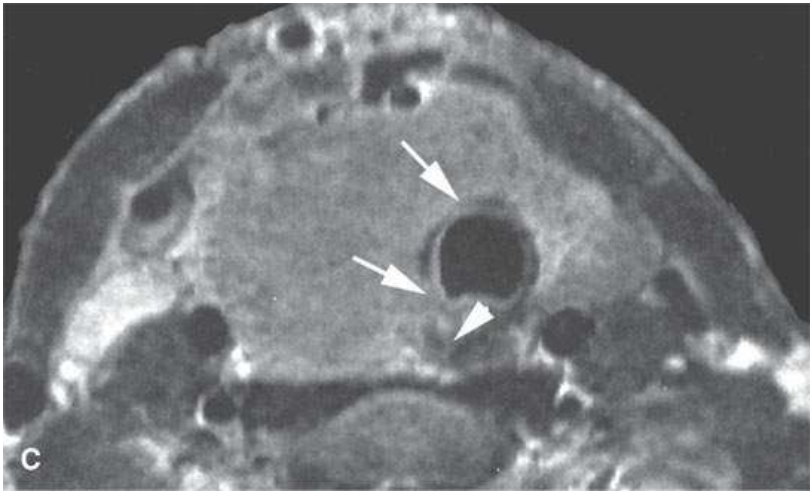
Three patients with anaplastic thyroid carcinoma. A: Contrast-enhanced computed tomography (CECT) of an early cancer (arrows) already encasing the carotid artery (arrowhead). B: CECT showing tracheal (white arrows) and esophageal invasion (black arrowheads) and displacement but not invasion of the carotid sheath structures (black arrow). C: T2-weighted image showing tracheal invasion (arrows) and esophageal invasion (arrowhead).
